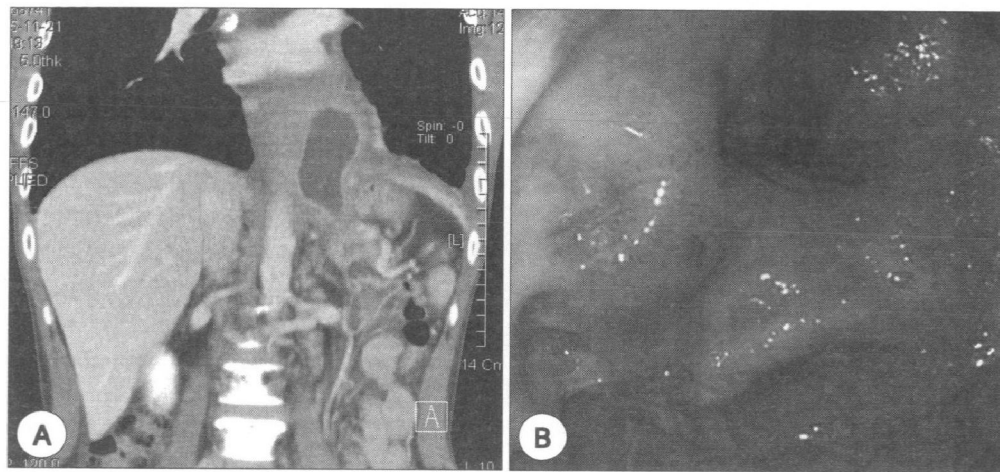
A : Follow-up CT scan. Marked decreased size of cystic lesion is observed. B : Follow-up endoscopy. There was no extrinsic compression in cardia except insertion scar.
